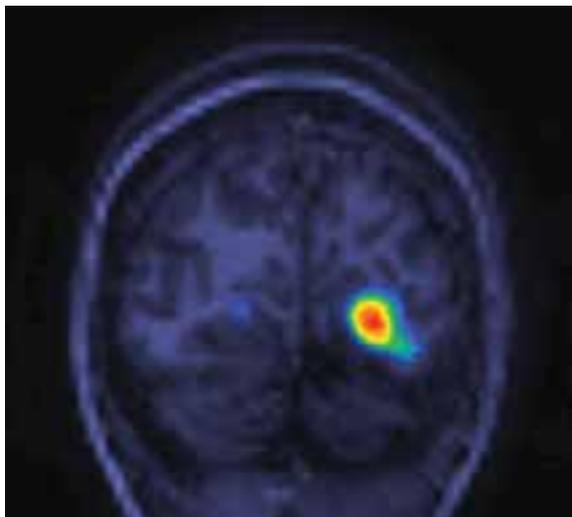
Case 1 – ictal SPECT
